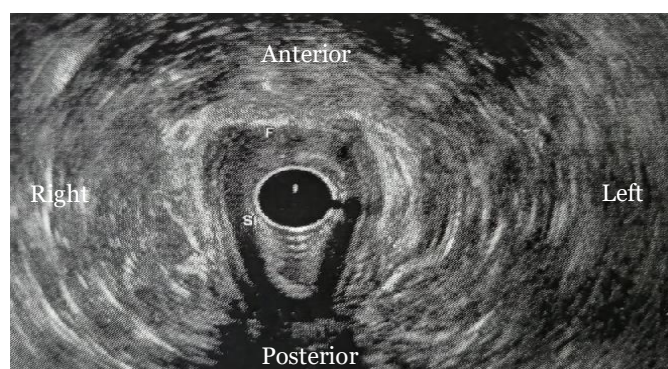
Endoanal ultrasound image showing a low transsphincter fistulas (F) with IAS defect (SI)
